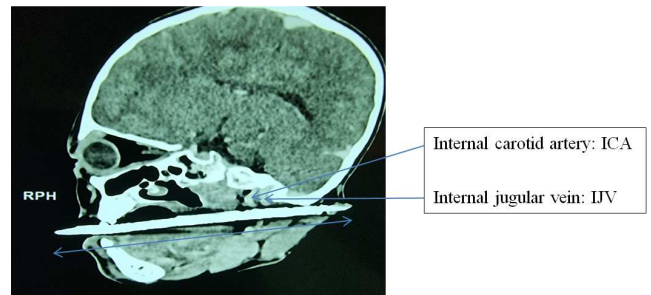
Cervicofacial CT: Visualization of a transfixing metallic density body passing in front of the jugulocarotidien axis.
